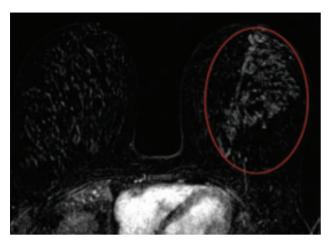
Contrast-enhanced magnetic resonance imaging of the breasts demonstrates an area of non-mass enhancement (red oval) in the left breast extending from the nipple to the posterior breast tissue
